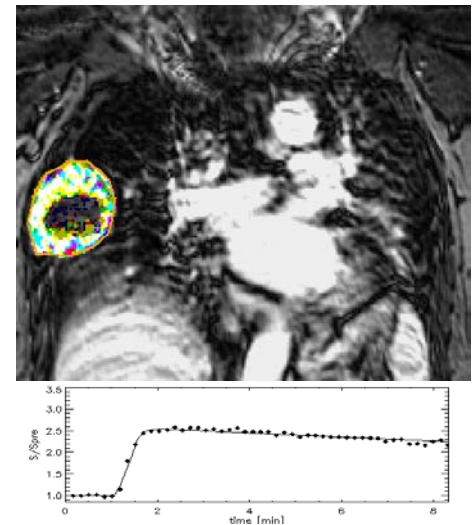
DCE-MRI parametric color-coded enhancement map overlaid on the morphologic image (upper) and time-intensity curve within the whole tumor ROI (lower).
